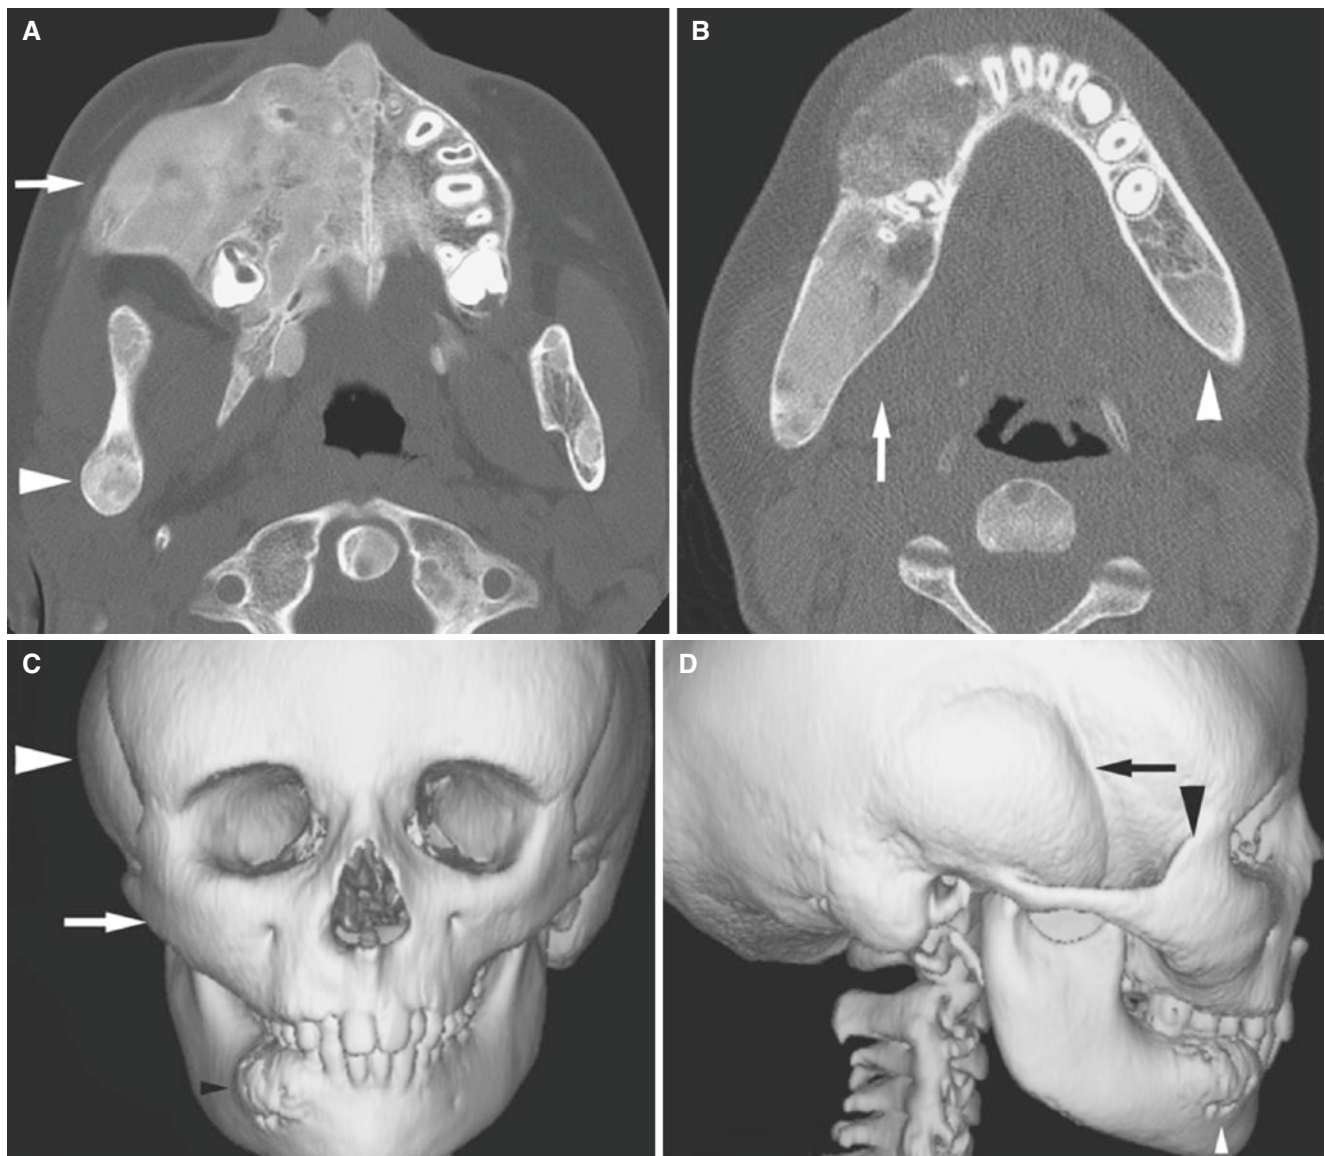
Craniofacial fibrous dysplasia; 11-year-old female with painless gradually increasing swelling of the right face and mandible. (A) Axial CT image shows typical ground-glass appearance of evidently expanded right maxilla (*arrow*) and of the right mandible (*arrowhead*). (B) Axial CT image shows ground-glass appearance of the entire right mandibular body (*arrow*) and also in the minor part of the left mandible
